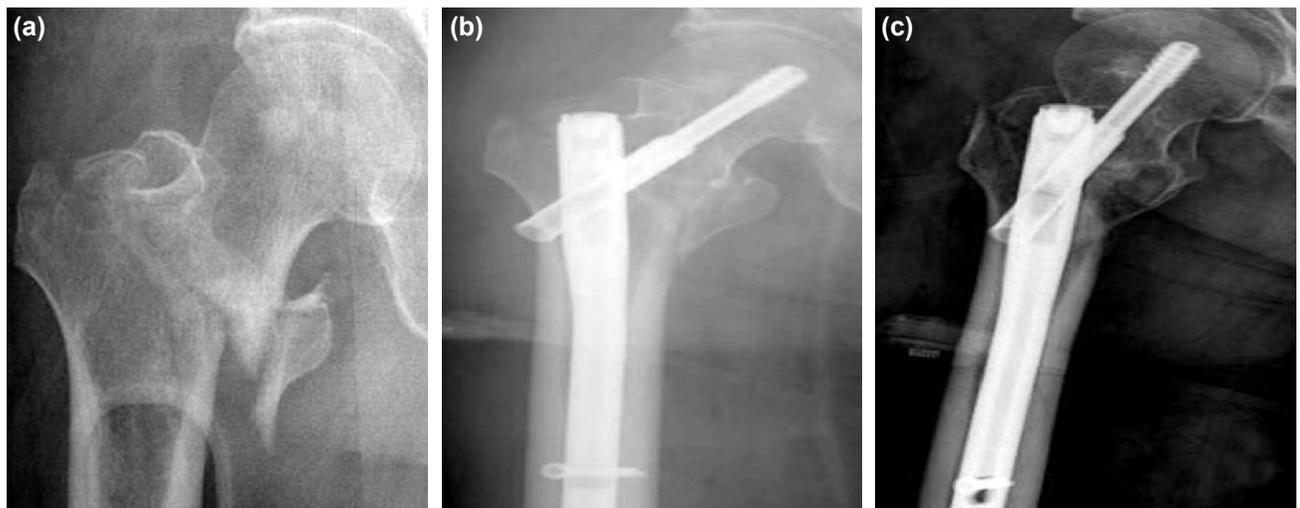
(a) Anteroposterior radiograph of an 83 years old man with an A2 type intertrochanteric femur fracture. (b) Postoperative anteroposterior radiograph of the fracture treated with PFN-A. (c) Postoperative lateral radiograph of the fracture treated with PFN-A.
